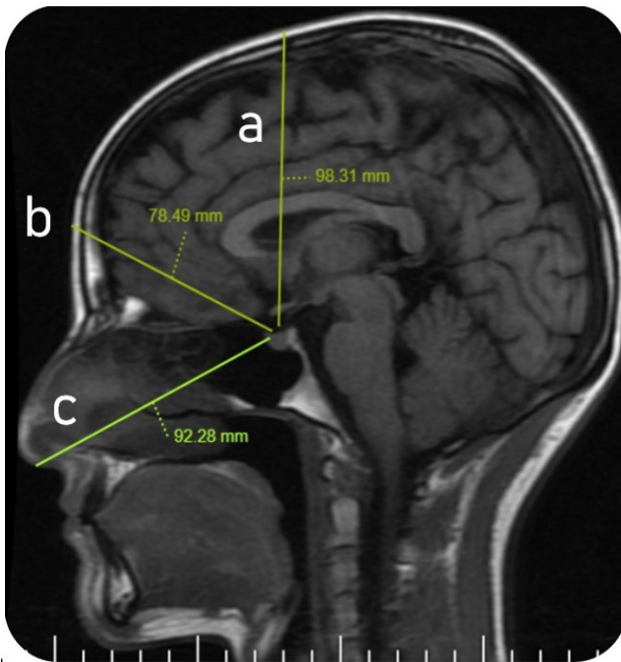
Measurement of frontoparietal (a), transcranial (b) and transsphenoidal (c) distance on the sagittal MRI image of an 18 years-old female.
